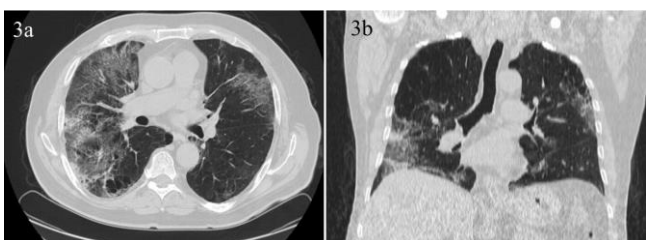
Axial and coronal plane images of Chest CT. Parenchymal ground glass infiltrations, more pronounced on the right
